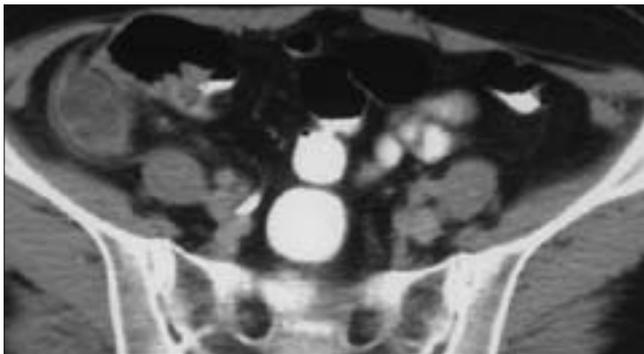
Axial CT image shows dilated appendix lumen filled with fluid, with thickened and enhanced walls, following the administration of intravenous contrast medium. Note the presence of an adjacent fluid collection.
